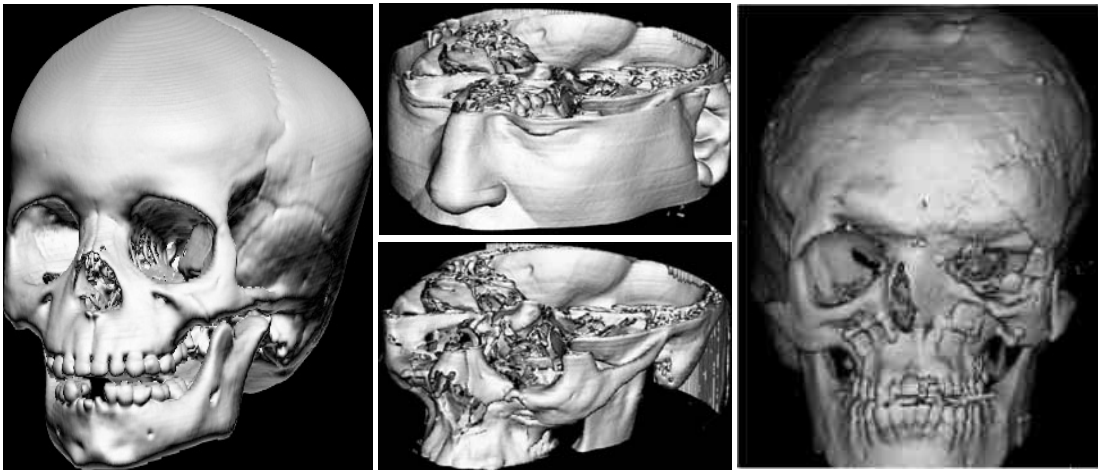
Direct rendering shaded volume from CT and MRI data. Left and middle surface rendering, right semi-transparent rendering
